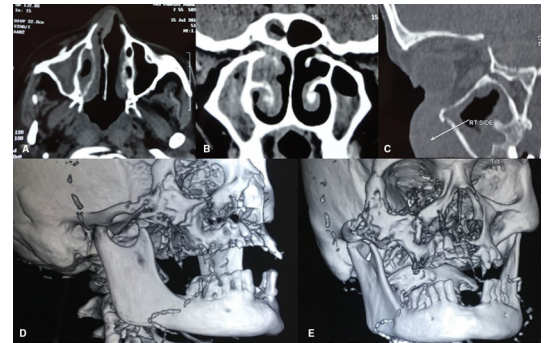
CT scan of the paranasal sinuses showing non-enhancing soft tissue density in sphenoidal, bilateral ethmoidal and frontal sinuses with concentric soft tissue densities and obliteration of osteomeatal openings. (A–C) Three dimensional CT scan showing erosion of the anterior maxilla. (D,E)
